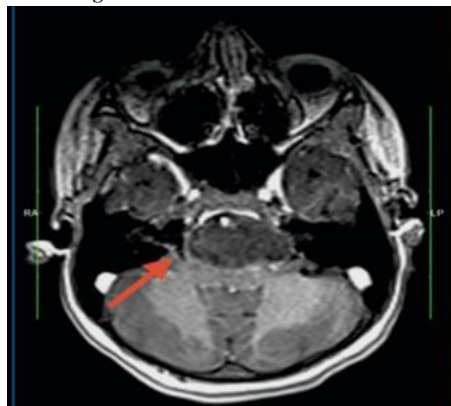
MRI Brain with contrast showing
